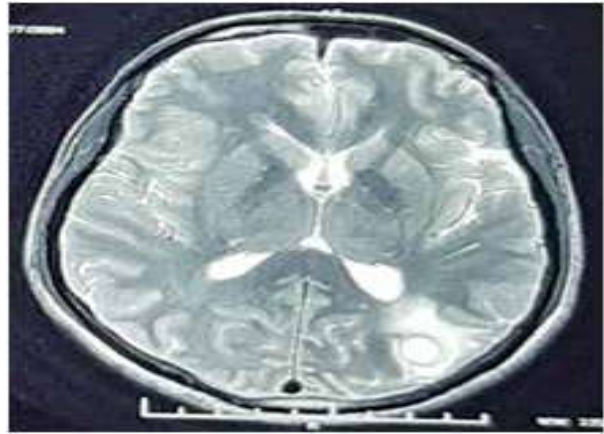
T2WI MRI Brain showing an active cyst with perilesional edema in left parietal region.
